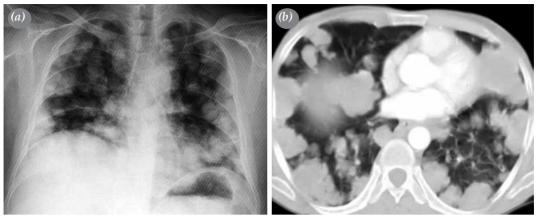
(a) Thoracic conventional radiography and (b) computed tomography scans of a 53-year-old male showing multiple alveolar echinococcosis lesions presenting as metastatic lung lesions (*Case 3*).
